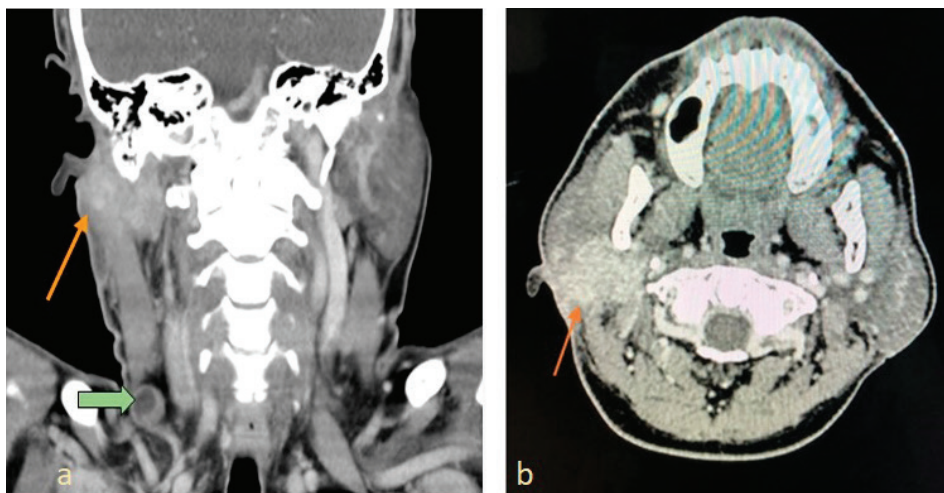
(a) Coronal CT scan shows an irregular shape contrast-enhanced right parotid tumour (thin arrow) with poor demarcated margin. The tumour is encroaching the soft tissue near the pinna and the stylo-mastoid foramen. An enlarged level IV lymph node with central necrosis is seen (thick arrow). (b) Axial CT scan shows ill-defined heterogeneous mass (arrow) involving both the superficial and deep lobes of the right parotid gland, and is seen extending medially, causing mild effacement of the parapharyngeal space
